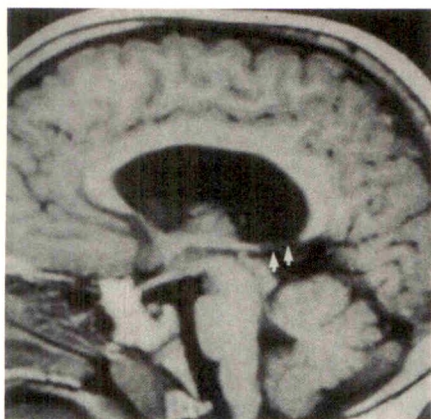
Midline sagittal SE 600/20 MR image of patient with septo-optic dysplasia. Fornix (arrows) is low in position, meeting splenium of corpus callosum posteriorly and inferiorly. Axial images of this patient showed absence of septum pellucidum.
